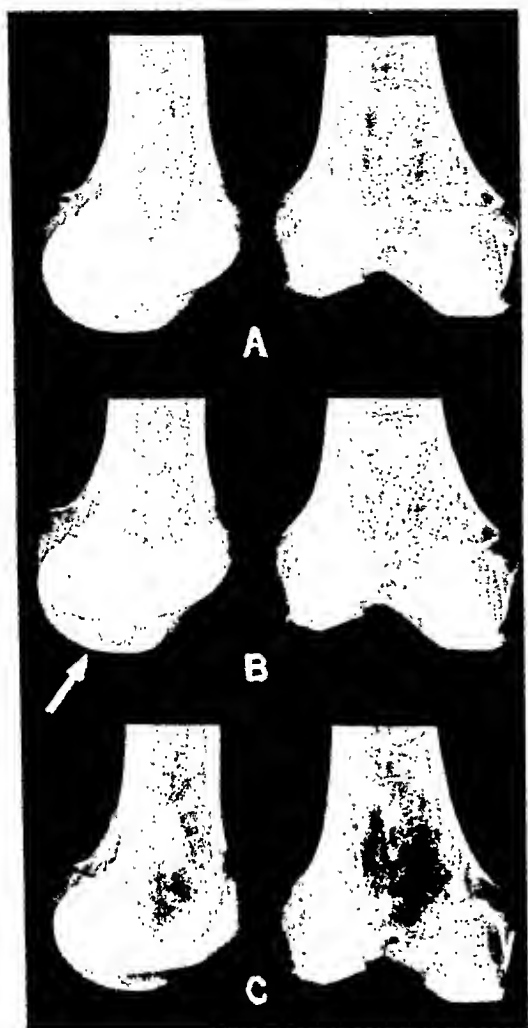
Roentgenogram of the distal end of a macerated femur.
